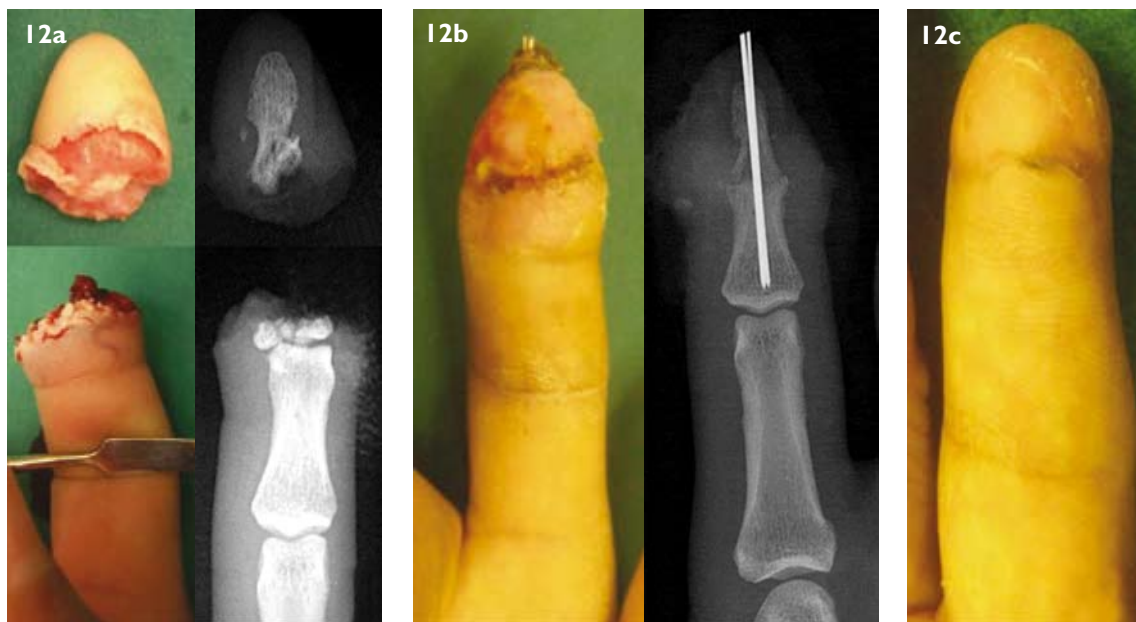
Distal replantation. Photographs and accompanying radiograph images show (a) a complete amputation through the distal phalanx and (b) the replanted finger one month postoperation, where the distal interphalangeal joint is fused. (c) The final results six months postoperation.
